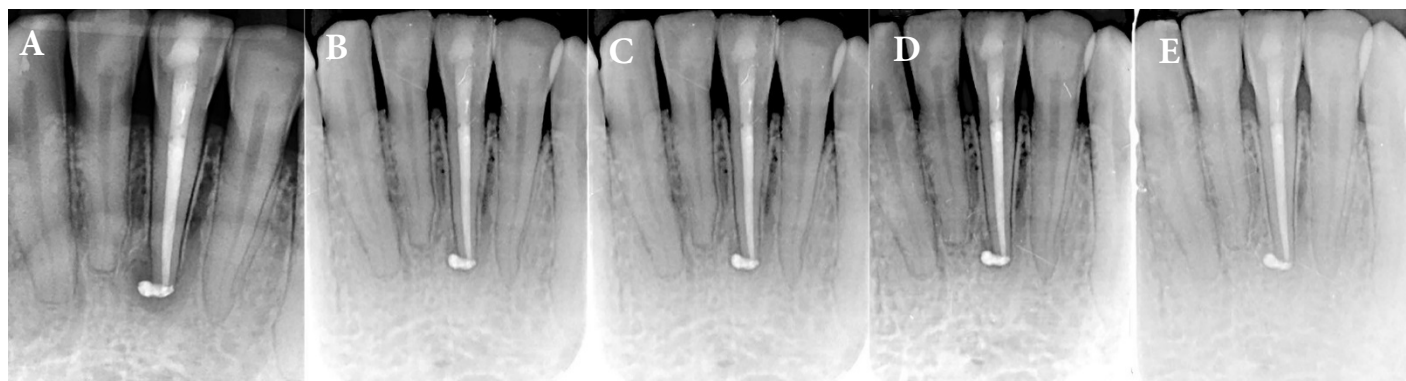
Radiographic controls; A) Immediately after root canal treatment (RCT); B) Six months after RCT; C) One year after RCT; D) Two years after RCT; E) Three years after RCT
